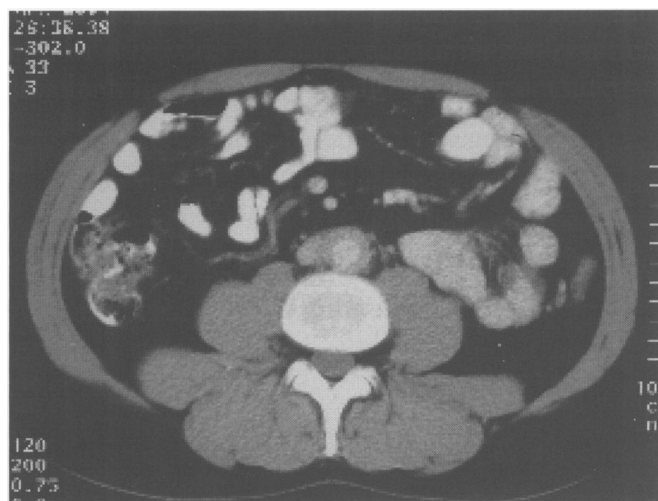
CT scan one year post treatment with steroids, at a similar level to fig 2, showing significant improvement.
